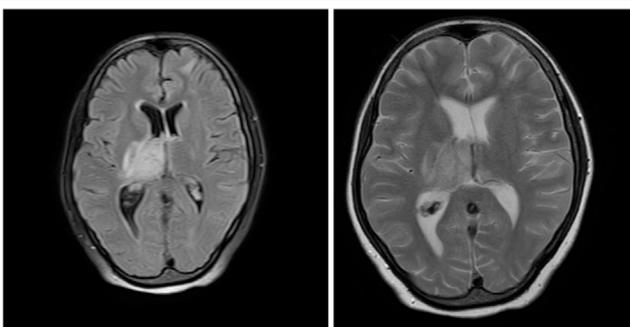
Fluid attenuated inversion recovery and T2-weighted magnetic resonance imaging brain axial view showing the choroid plexus in right trigone and right choroid fissure are bulky and appear Hypointense on T2W images suggestive of choroid plexus haemorrhage.
